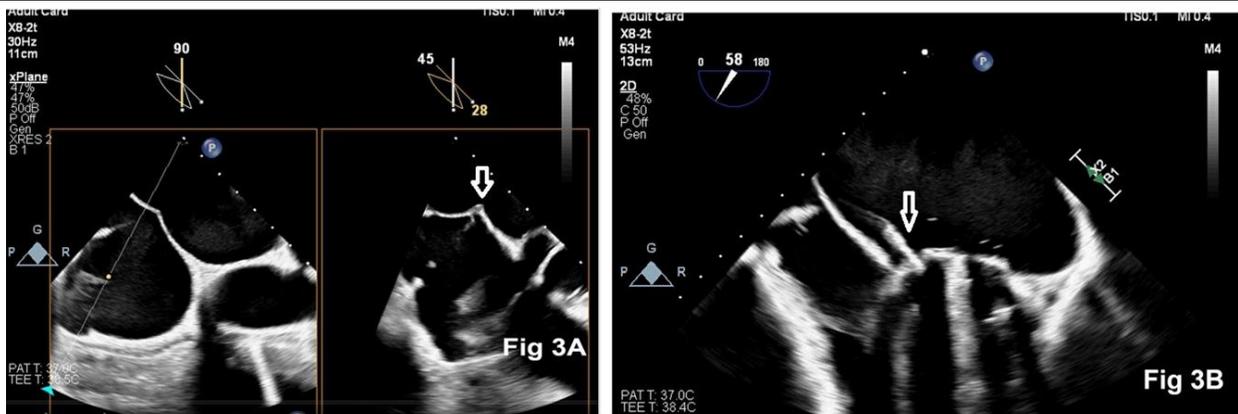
Two-dimensional echocardiography showing trans-septal puncture (Fig 3A) and a steerable introducer sheath positioned at the paravalvular leak (Fig 3B)
